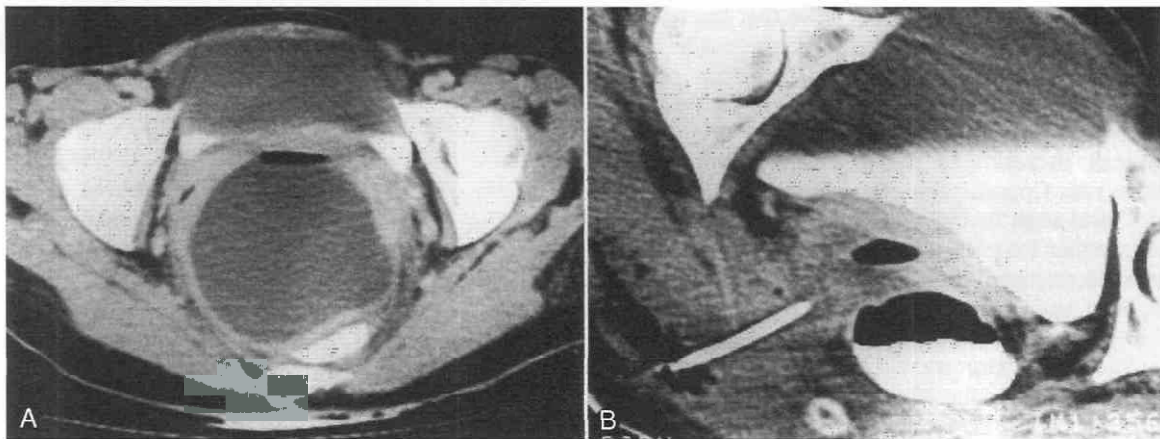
A*, CT scan of the pelvis shows a large abscess posterior to the bladder and anterior to the rectum. *B*, Follow-up scan shows catheter drainage through the sciatic notch. Note that the cavity is much smaller, but there is also an abscess that has tracked posteriorly into the gluteal muscle.
